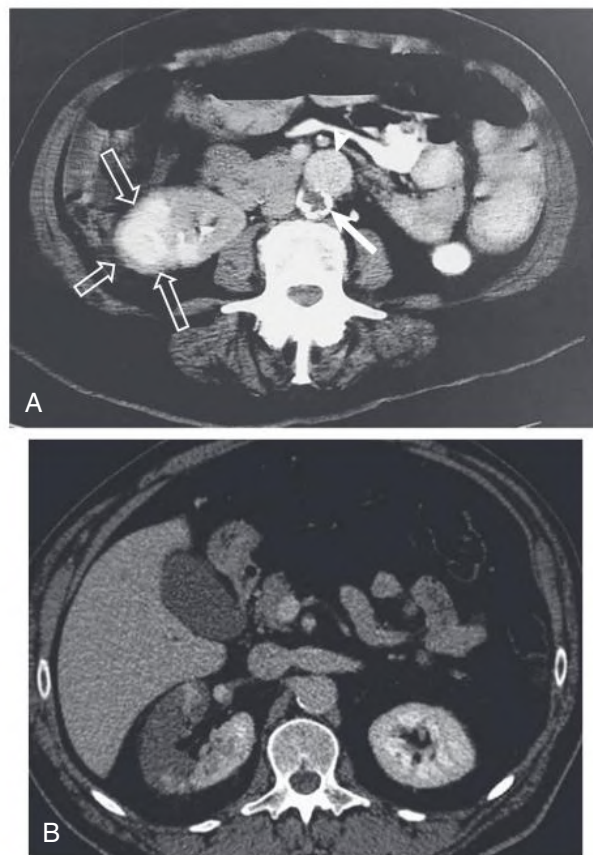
Renal Infarction. (A) Computed tomography (CT) scan showing a chronic calcified infarct (*open arrows*) involving half of the right kidney after aortic bypass surgery. The native aorta has a densely calcified wall (*arrow*). The aortic graft is anterior to the native aorta (*arrowhead*). (B) CT scan showing acute infarct in the right kidney with decreased parenchymal enhancement (*arrows*).
